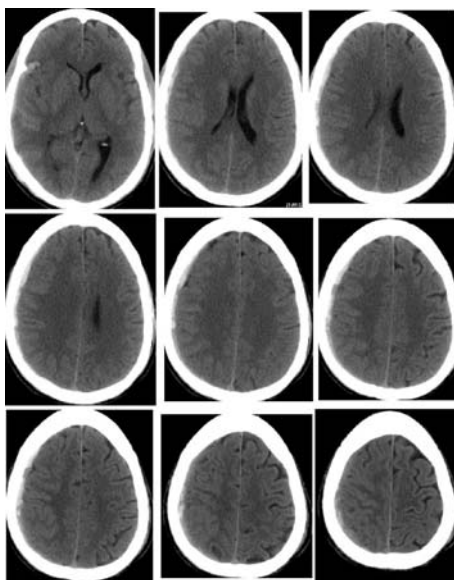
CT scan showing significant resolution of acute SDH. There is evidence of subarachnoid hemorrhage.
